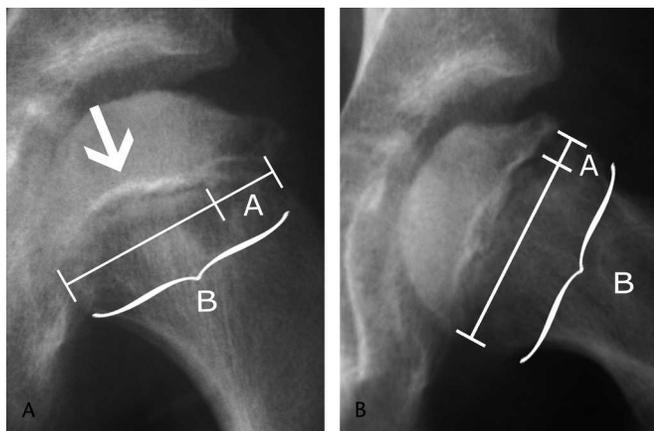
(A) Measurement of growth plate involvement is shown on (A) AP and (B) frog leg radiographs. Distance A is the involved part of the growth plate and distance B is the width of the physis. The arrow points to the margin of the growth plate (growth plate involvement = A/B [AP] \times A/B [frog leg]) (growth plate involvement = 0.037).
